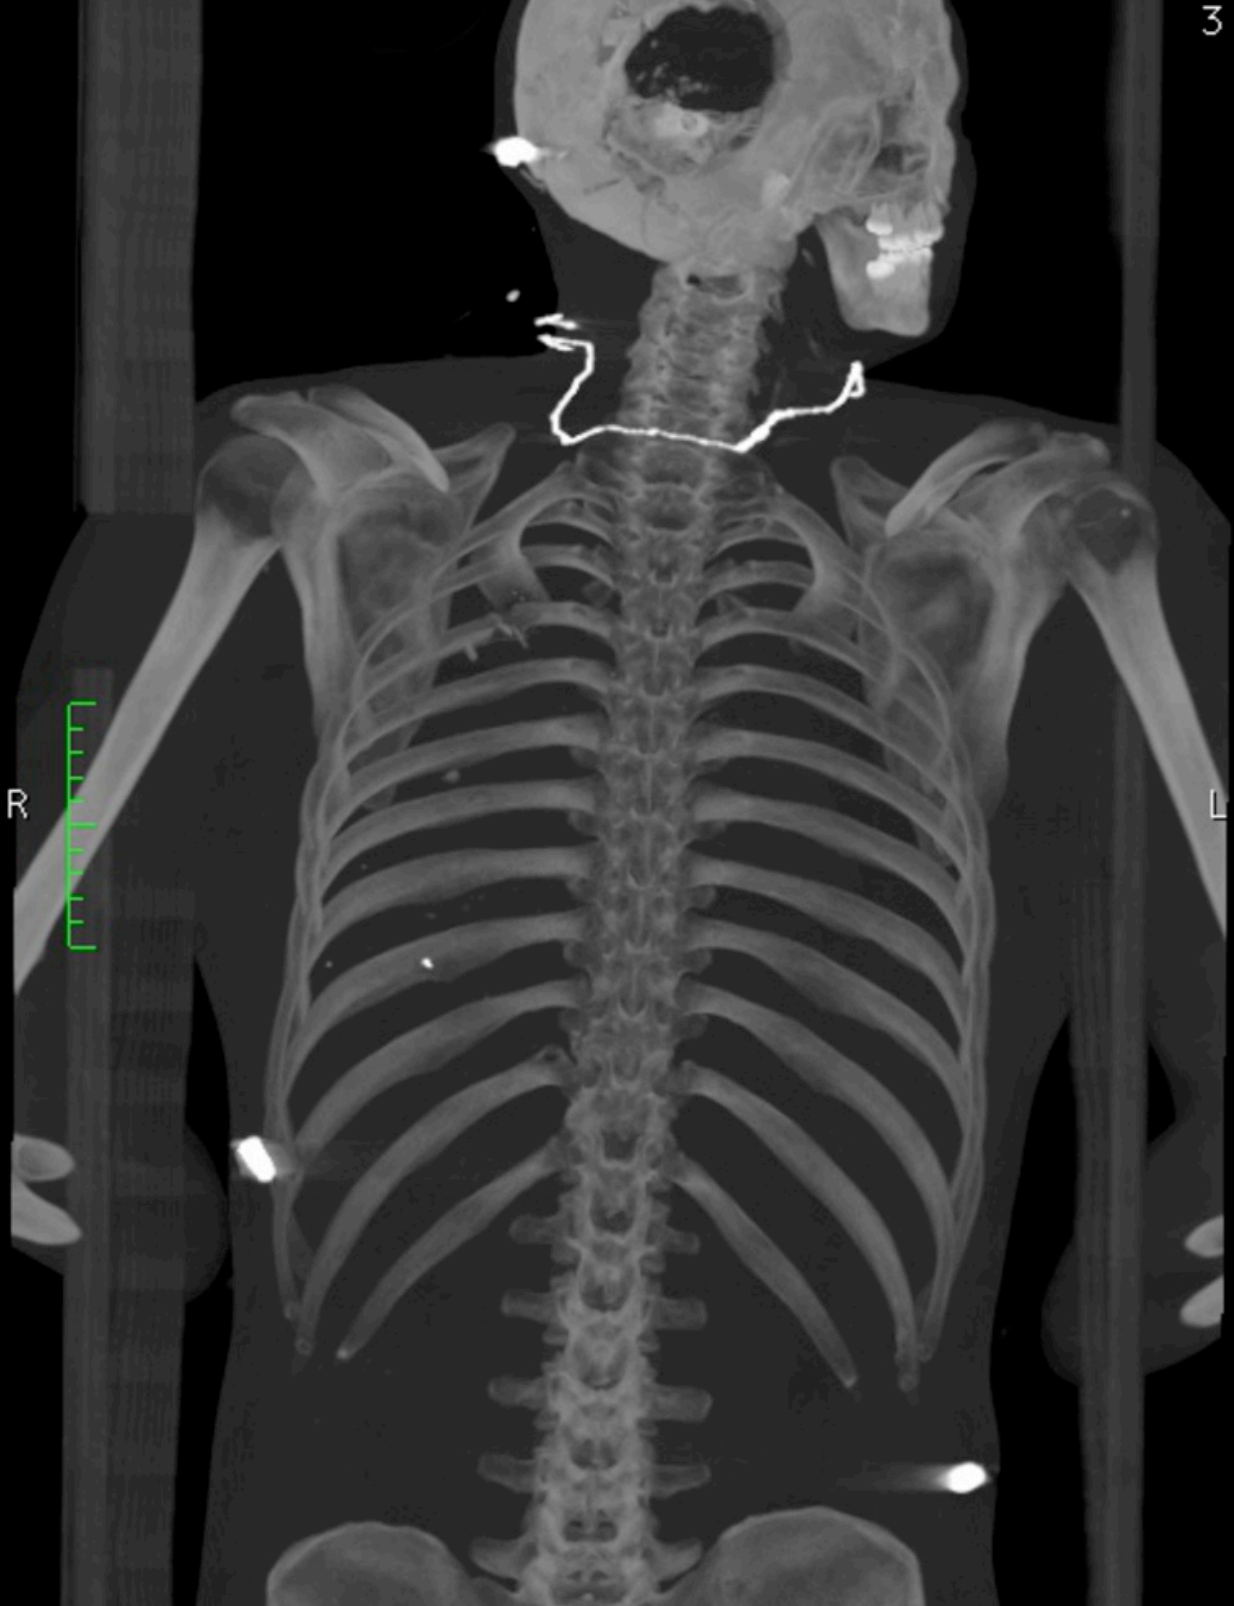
CT Axial MIP reconstruction of bullet trajectory through the chest
